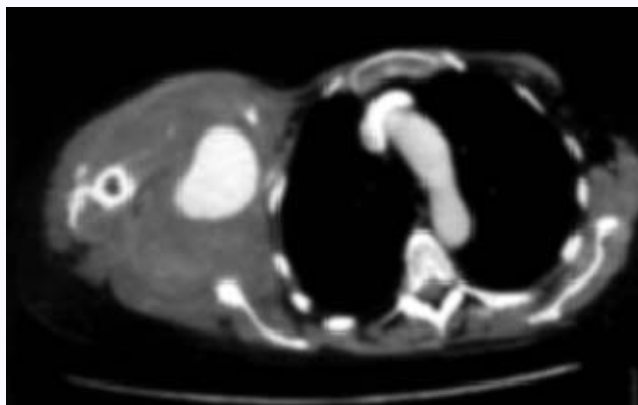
Contrast-enhanced helical CT through the right axilla showing contrast filling of the false aneurysm lumen.
